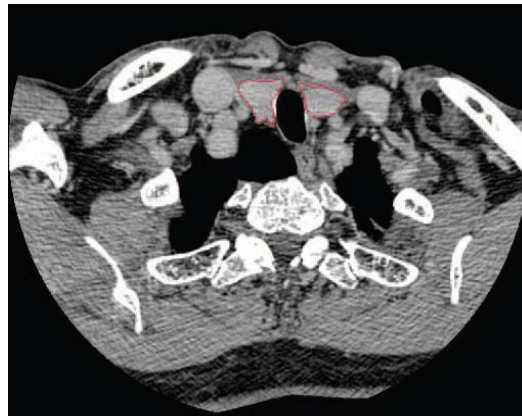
CT Image (thyroid regions are outlined in red) [11]
